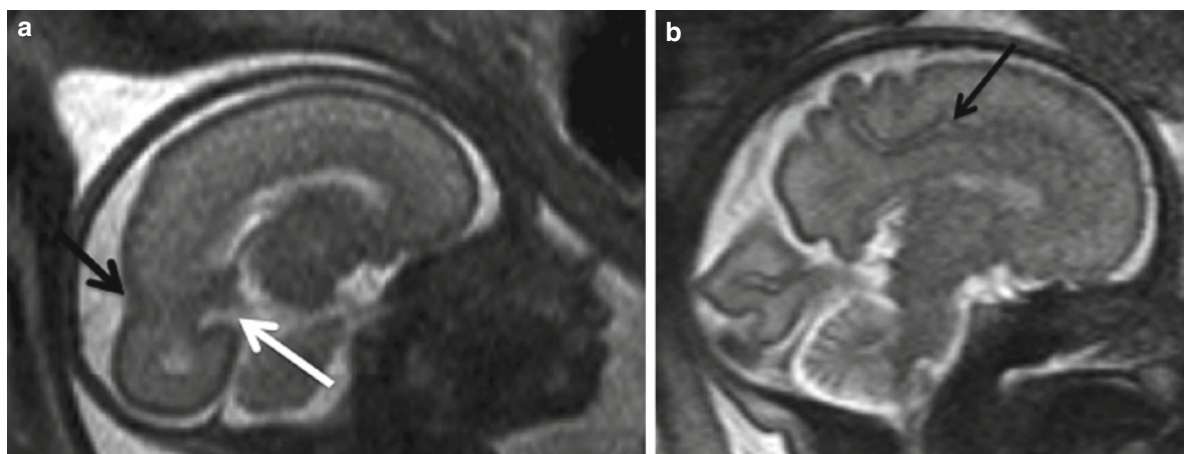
Sagittal T2-weighted sequences of a fetus at 24+0 GW (a) and 32+0 GW (b). On image (a) the parieto-occipital sulcus (black arrow) and the calcarine sulcus (white arrow) are visible. Note the cingulate gyrus on image (b)
